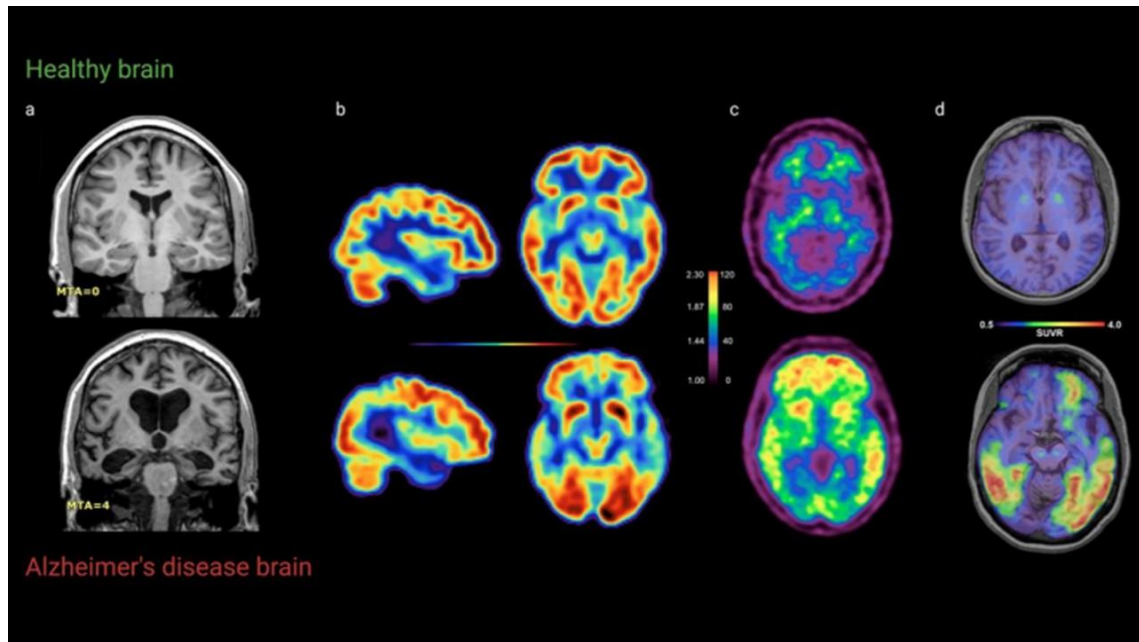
Neuroimaging of the healthy brain versus Alzheimer's disease, with structural MRI, [^{18}F]FDG-PET, amyloid-PET, tau-PET (source: van Oostveen et al., 2021).
